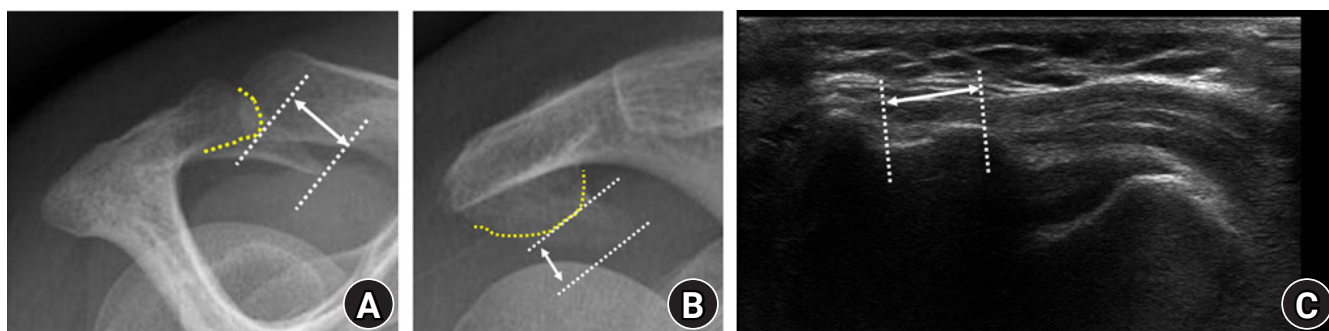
Right shoulder of a 59-year-old woman. (A) The length (arrow) from the anterior acromion (yellow dotted line) to the most projected point of the acromial spur was measured on supraspinatus outlet-view radiographs. (B) The length (arrow) from the most distal margin of the original acromion (yellow dotted line) to the most projected point of the acromial spur was measured on 30° caudal-tilt view radiographs. (C) Length of the acromial spur (arrow) measured on a sonogram.
